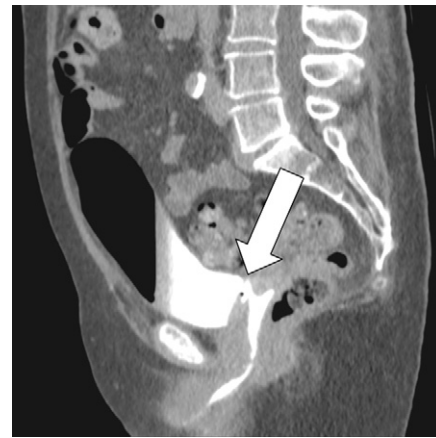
Vesicovaginal fistula. Contrast-enhanced CT scan, delayed phase acquisition: passage made visible due to the intravaginal presence of the contrast medium (arrow).
